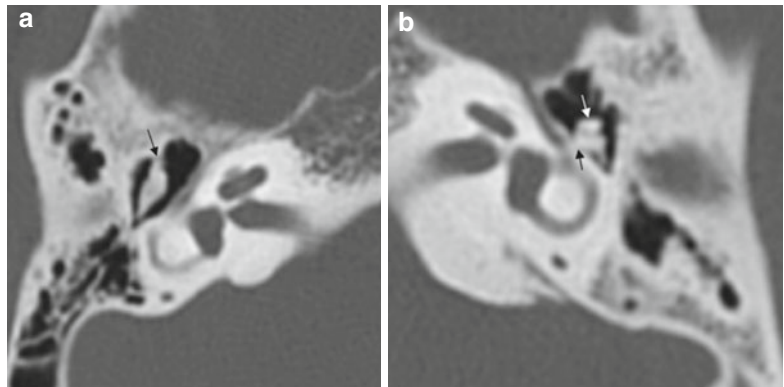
(a) Transversal computed tomography of a right ear: bony bridge (arrow) between the malleus head and the tegmen. (b) Transversal computed tomography of a left ear with fixation of the incus on the medial attic wall (black arrow), malleus head (white arrow)
